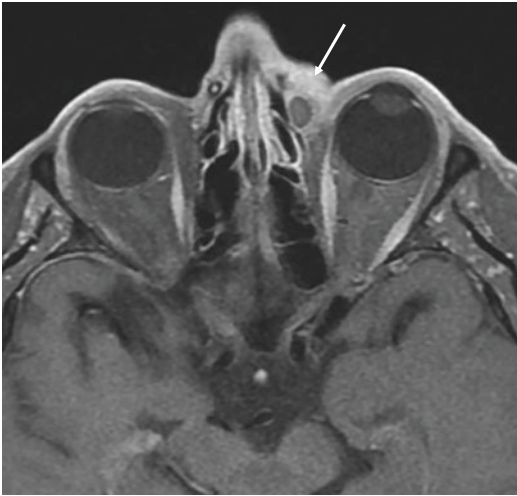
Axial fat saturated T1 weighted MRI post contrast revealing a rim enhancing fluid collection with surrounding fat stranding at the medial canthus of the left orbit (white arrow) along the upper border of the left lacrimal duct. The sinuses are largely clear
